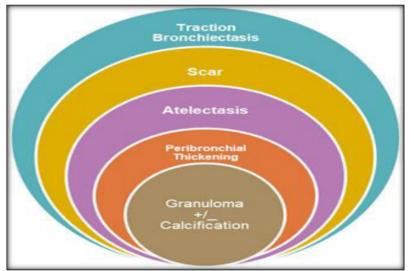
HRCT patterns of inactive tuberculosis
